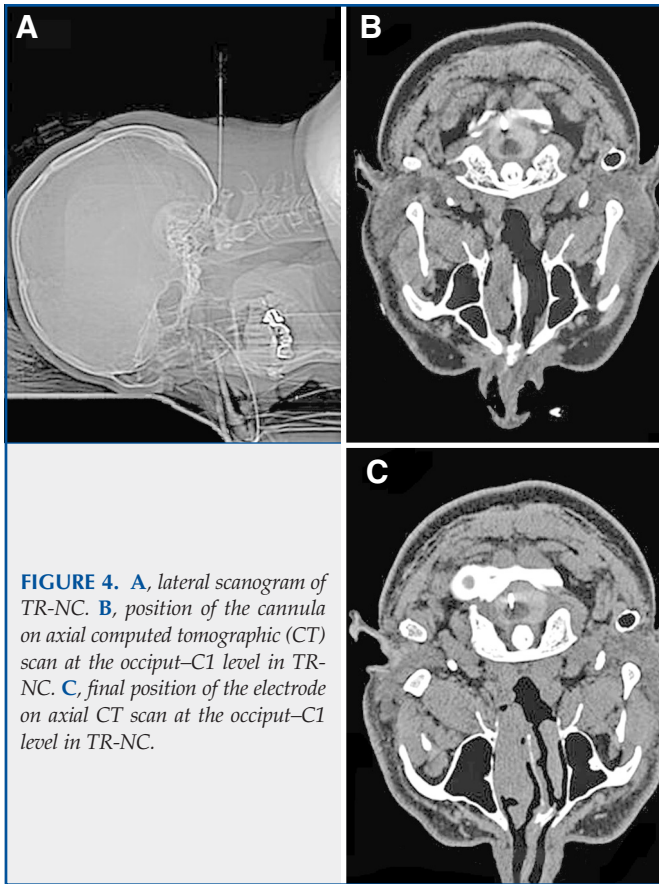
A, lateral scanogram of TR-NC. B, position of the cannula on axial computed tomographic (CT) scan at the occiput-C1 level in TR-NC. C, final position of the electrode on axial CT scan at the occiput-C1 level in TR-NC.
